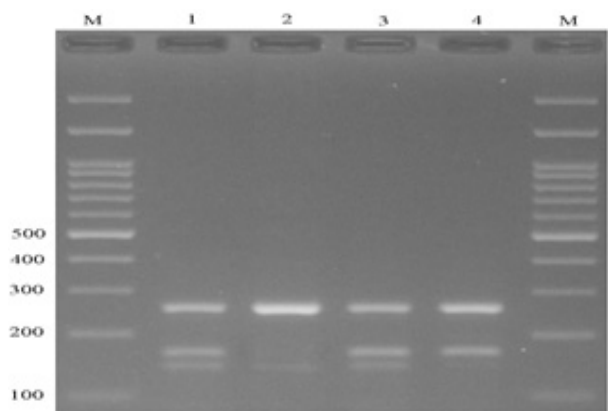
Photograph of the T-ARMS Method for the detection of miR-143/145 rs353292. Lane 1 and 3: CT; lane 2: TT; and lane 4: CC. T-ARMS: Tetra amplification-refractory mutation system
